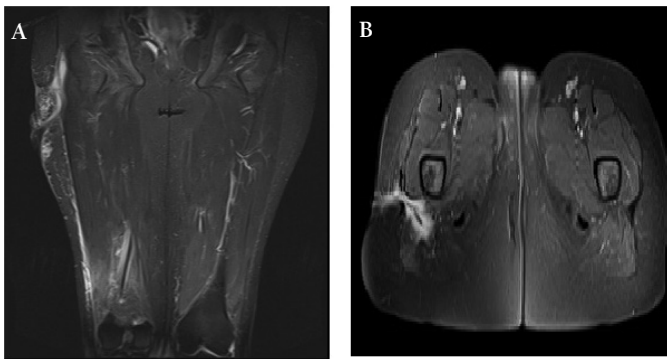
Axial fat-sat T2 weighted contrast enhanced T1-weighted A) Coronal and B) Axial images demonstrate active fistul tract extended laterally to the femur with secondary (external) opening on the thigh skin
